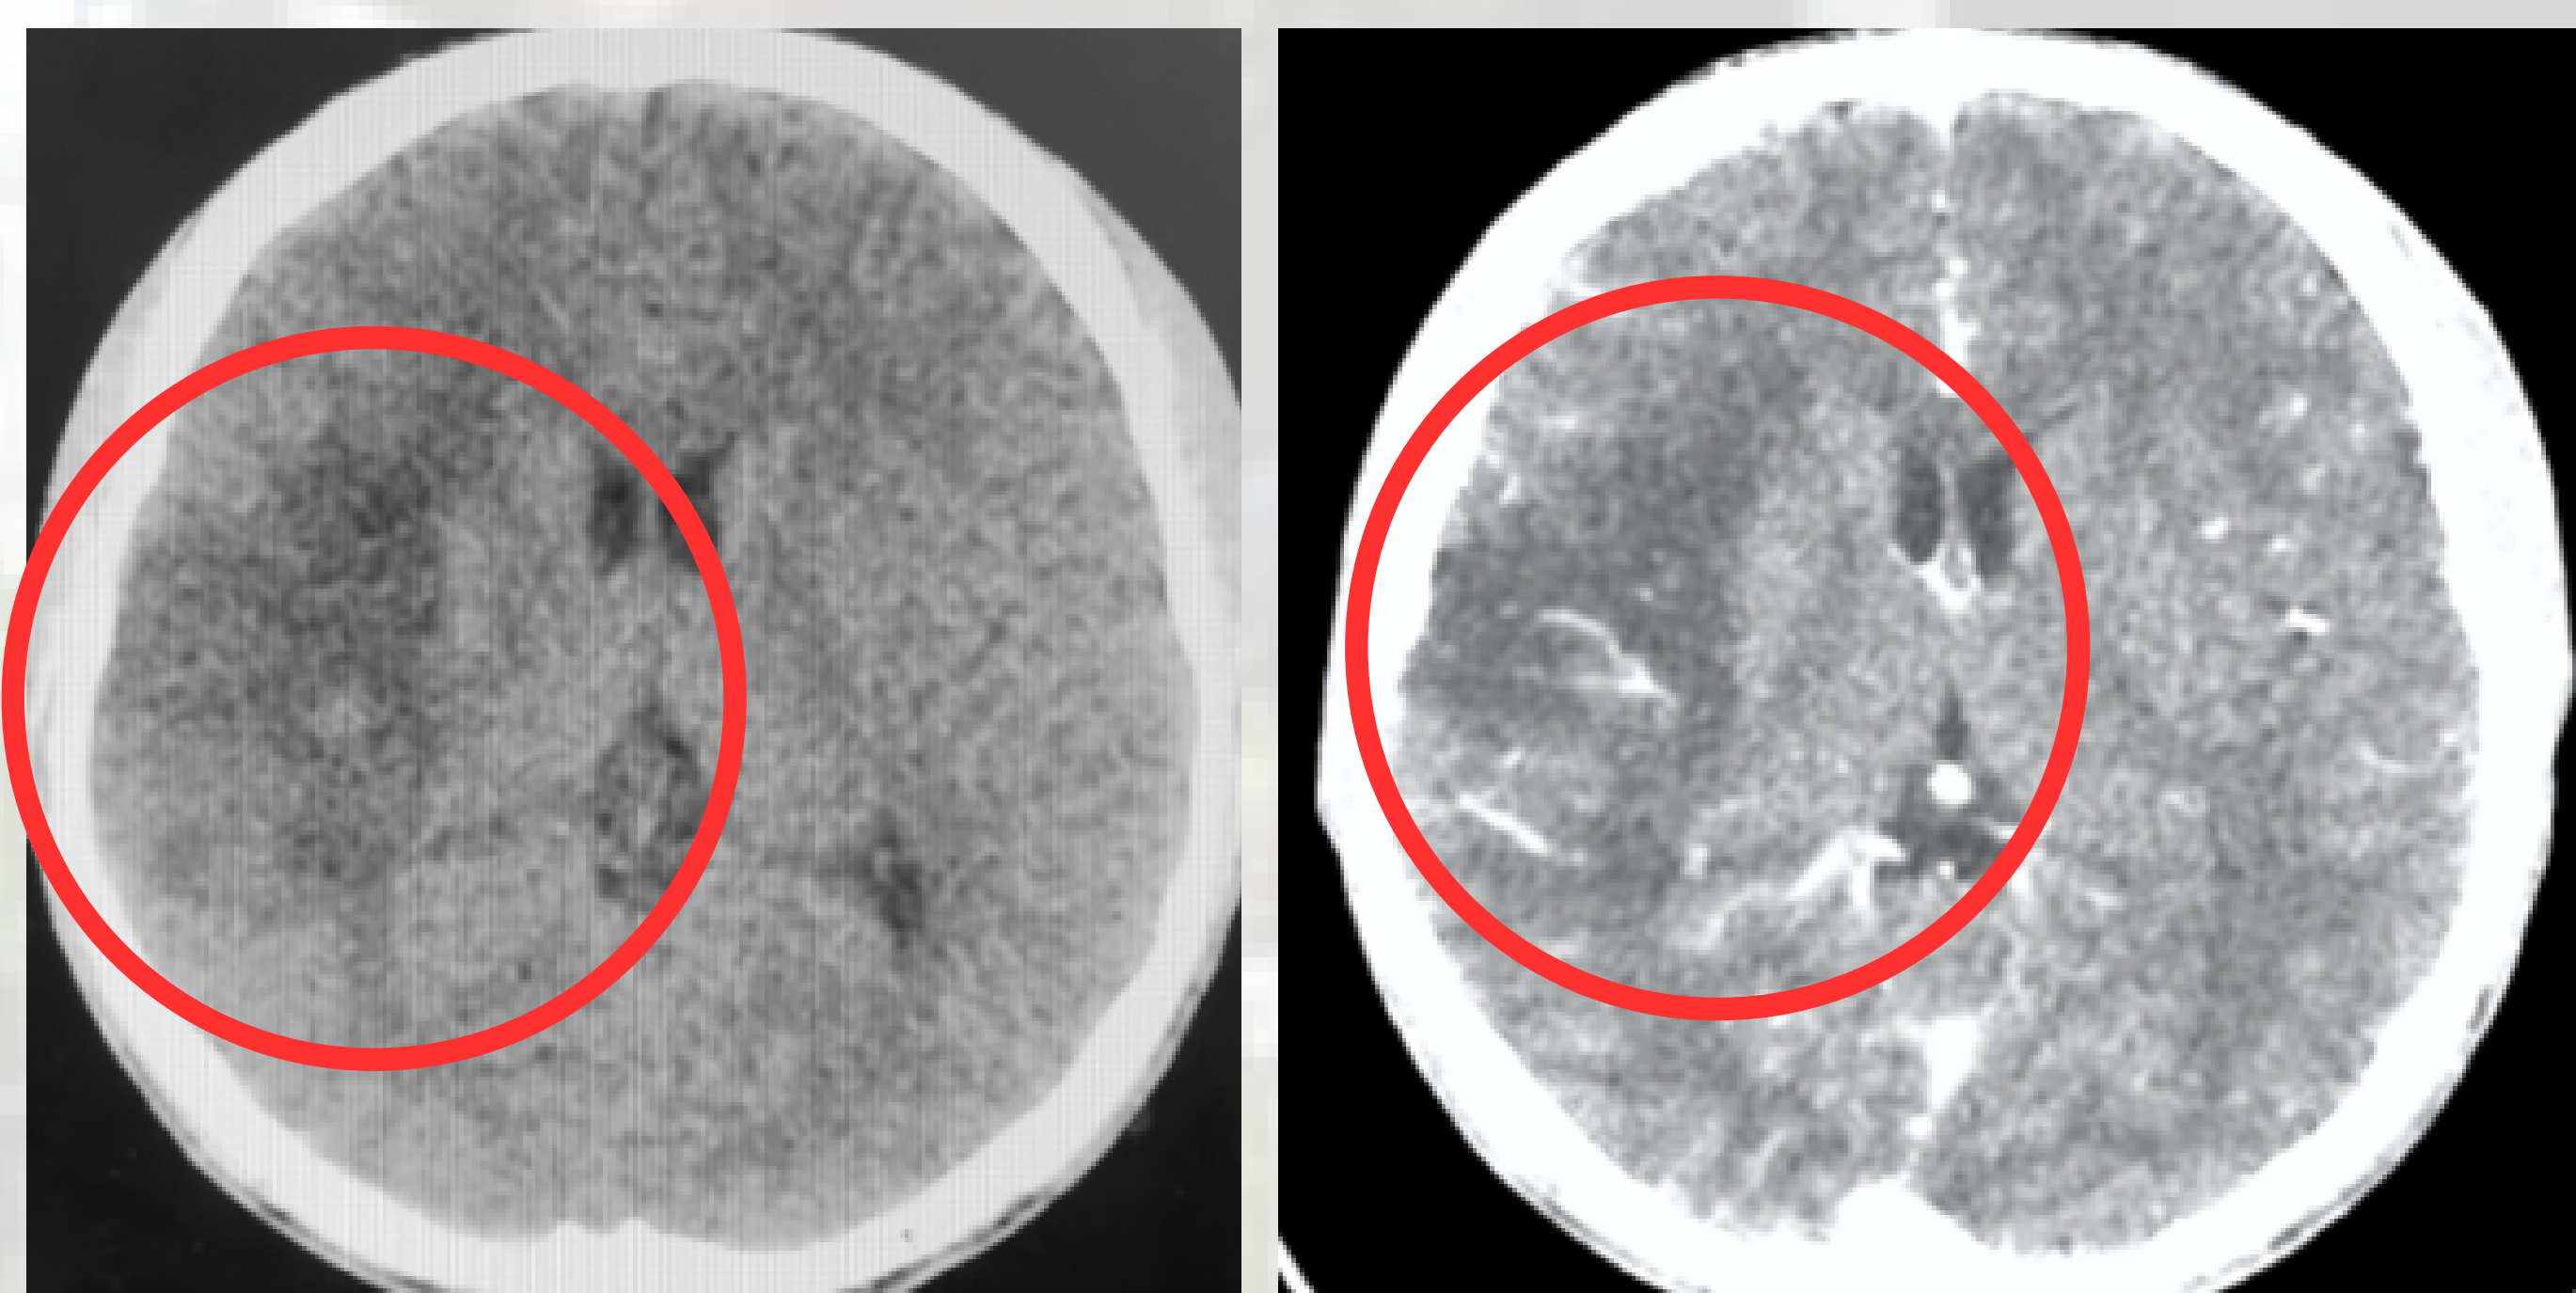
CT scan cranial plain and with contrast shows acute infarct, right MCA territory. 3B. CT scan cranial with contrast shows irregular enhancements with cortical hypodensities similar to Early Cerebritis.
